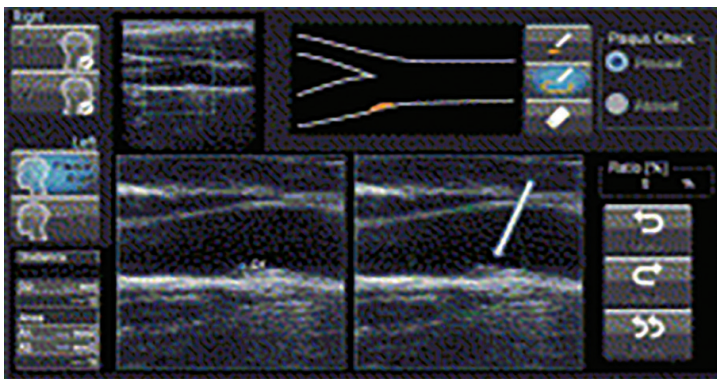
Ultrasonography of carotid arteries B.
